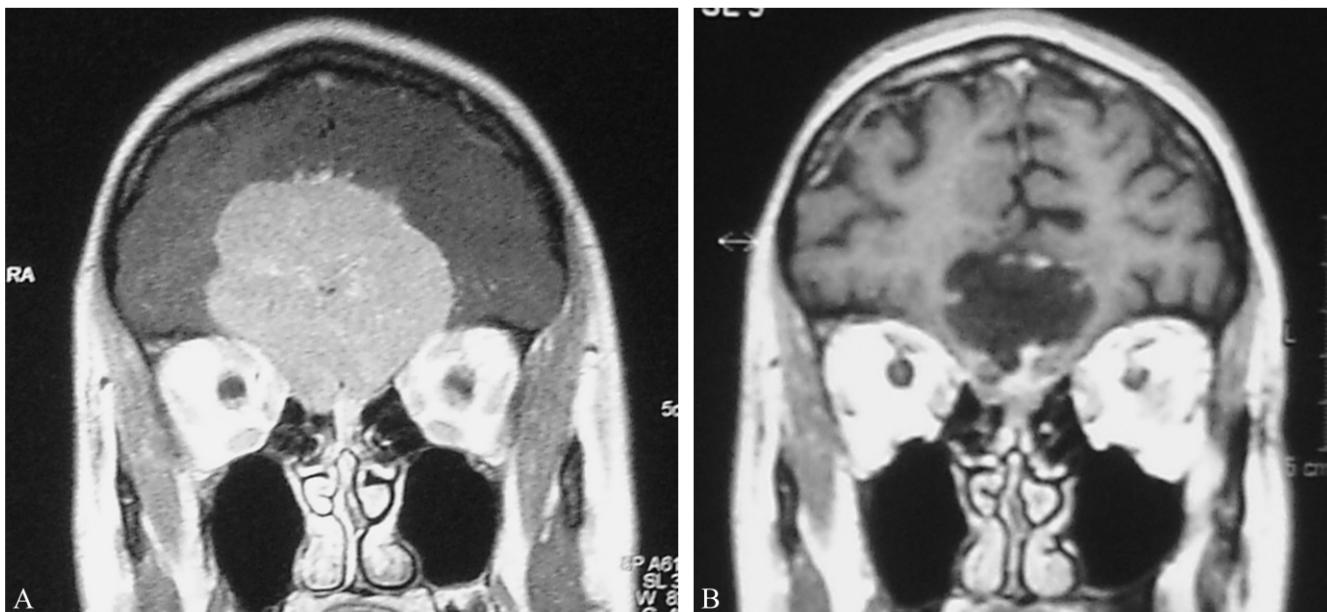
A) Coronal MRI T1-weighted images after gadolinium injection reveals a large OGM with the adjacent frontal gyri laterally dislocated; B) repositioning of the superior and orbital frontal gyri after tumor removal.
